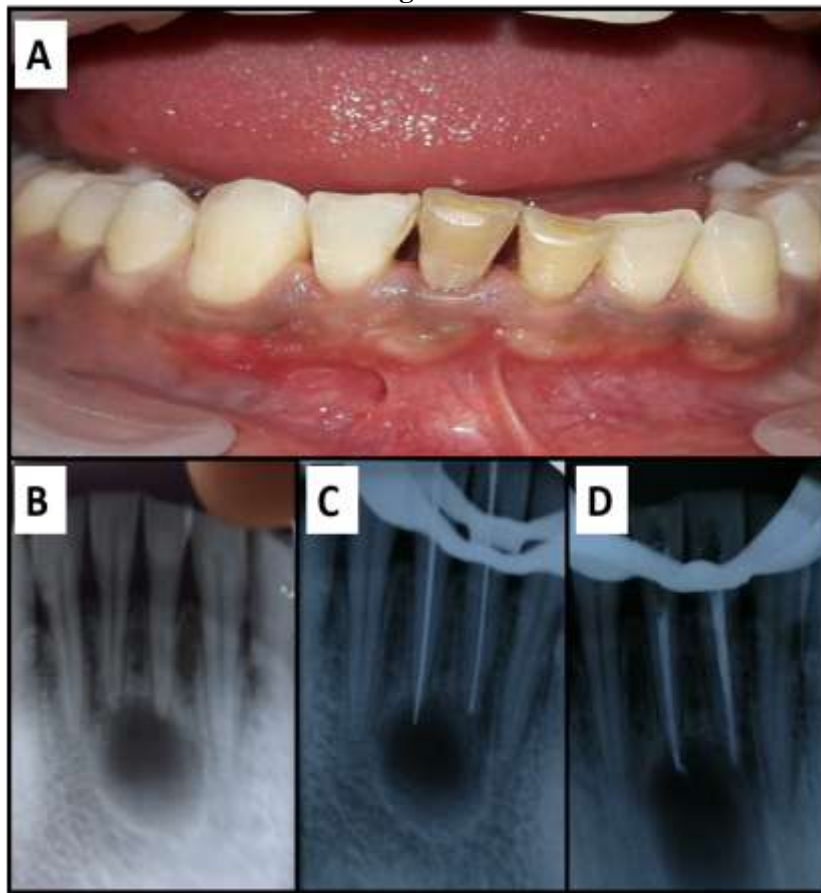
a) Pre-operative clinical photograph, b) Pre- operative radiograph, c) Working length determination, d)
